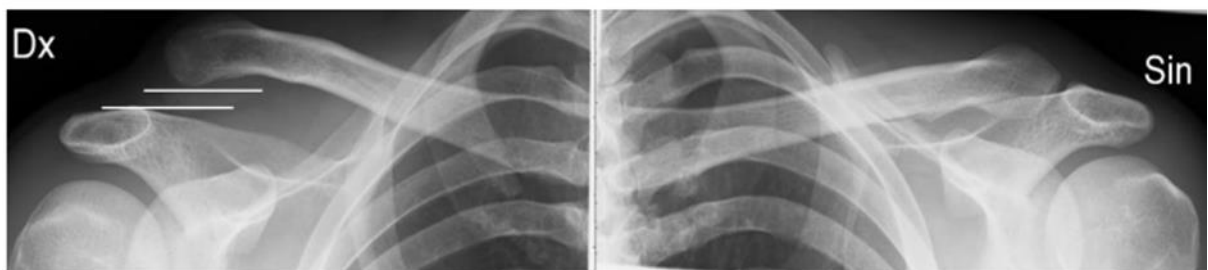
Antero-posterior radiograph of an AC joint with AC joint dislocation on right side. Dislocation in the AC joint is marked by white lines.
